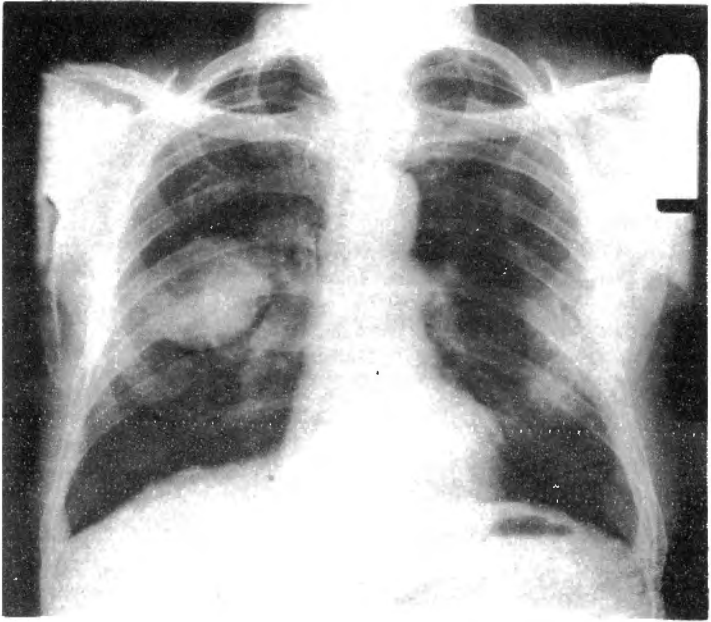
Radiographs showing right sided mass with bilateral pleural and diaphragmatic calcification. Malignant mesothelioma from Sanhıdır.
